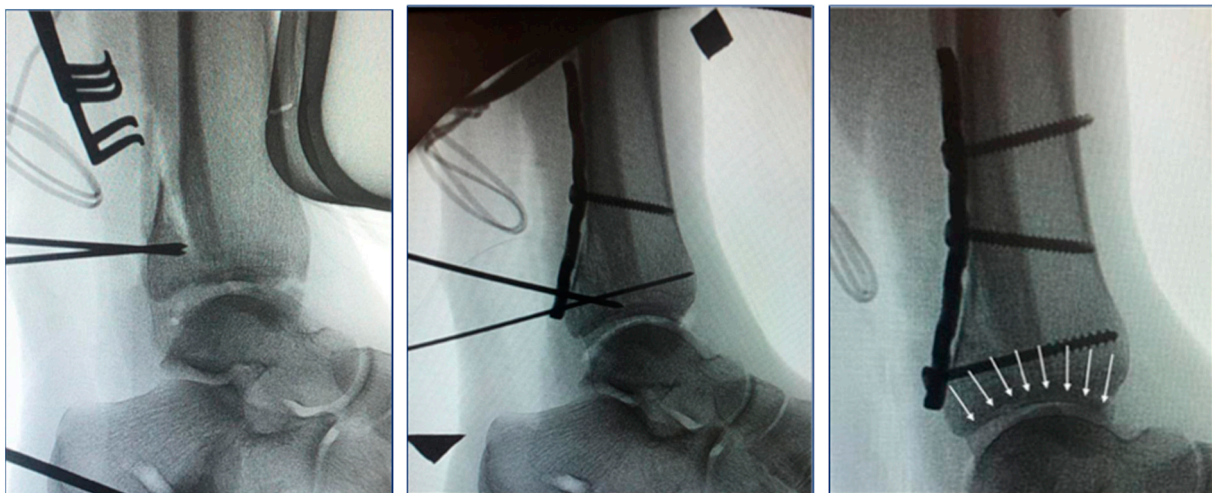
Intraoperative X-rays of posterior malleolus internal fixation with plate with articular surface correct reconstruction (white arrows).
